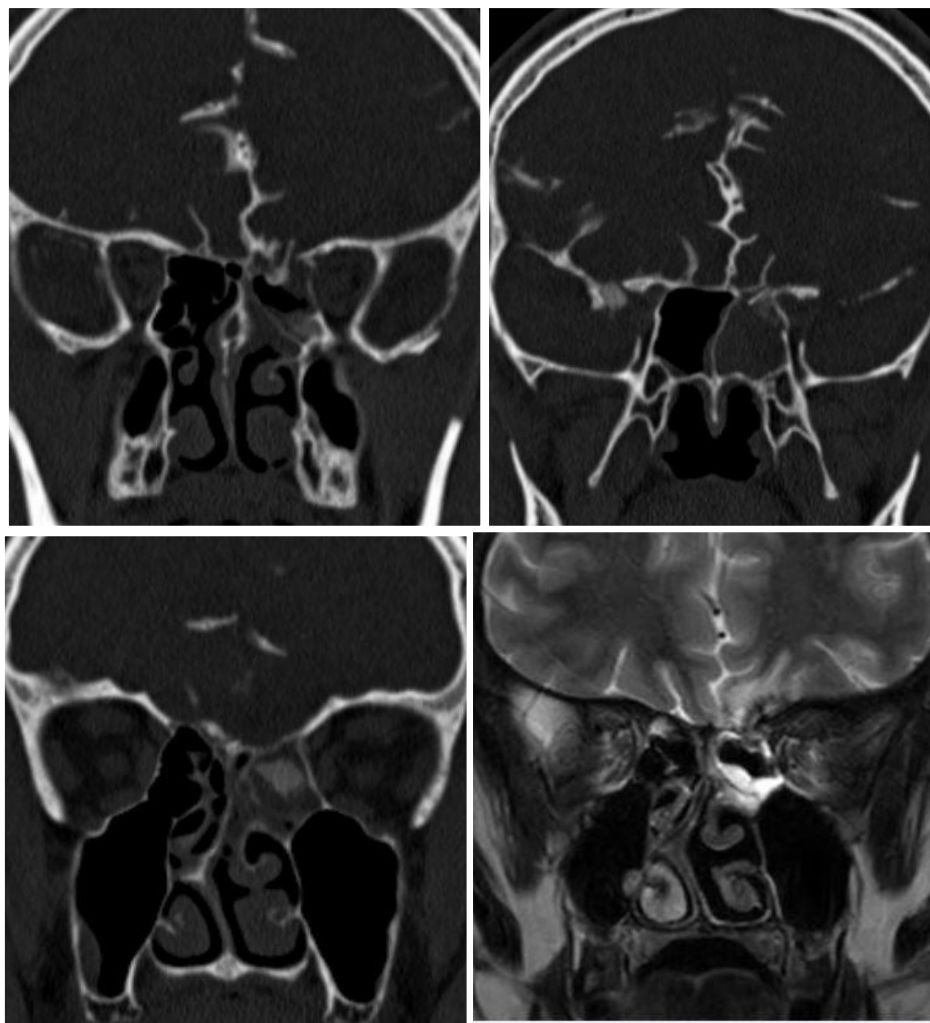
CSF cisternogram coronal images show bony defect in the ethmoidal and sphenoid roof with CSF leak opacifying the ethmoid and sphenoid sinuses. T2 W MRI sequence show stalk of brain parenchyma herniating through the defect with gliotic changes in the frontal lobe consistent with post traumatic ethmoid encephalocele.
